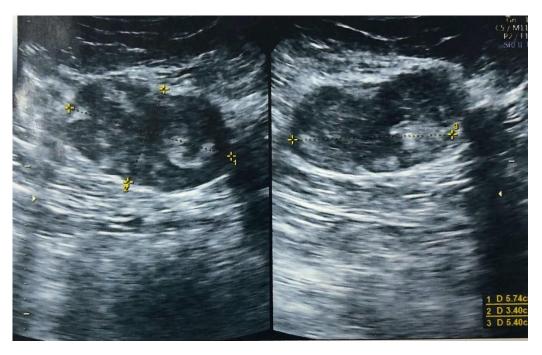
Ultrasound picture of the right breast
